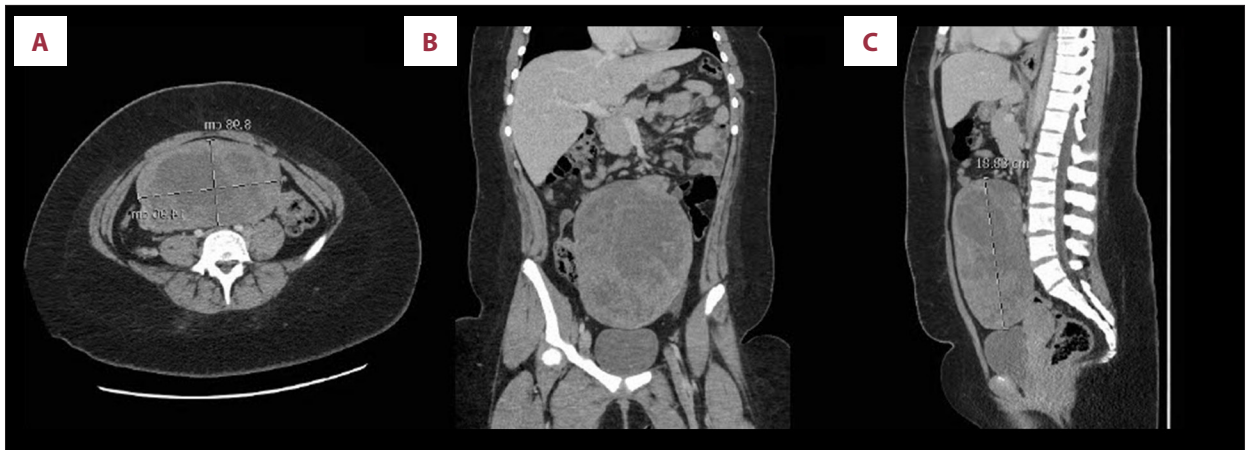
Computed tomography (CT) abdomen and pelvis with contrast. (A) Axial view of CT abdomen and pelvis of the juvenile granulosa cell tumor measuring 8.98×16.96 cm. (B) Coronal view of CT abdomen and pelvis of the juvenile granulosa cell tumor. (C) Sagittal view of CT abdomen and pelvis of the juvenile granulosa cell tumor with its height measured at 18.83 cm.
